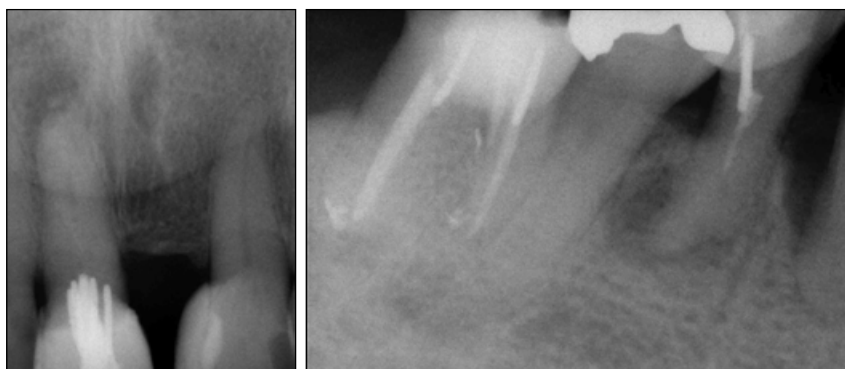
Periapical radiographs demonstrate periapical infections associated with the 11 and 44.
